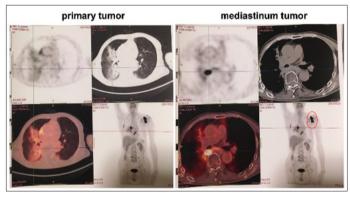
PET-CT imaging before final surgery. The primary tumor had much low metabolic activity compared to the mediastinum metastasis. The shoulder metastasis (indicated by the red circle in the lower right panel) had very high SUV signal.
